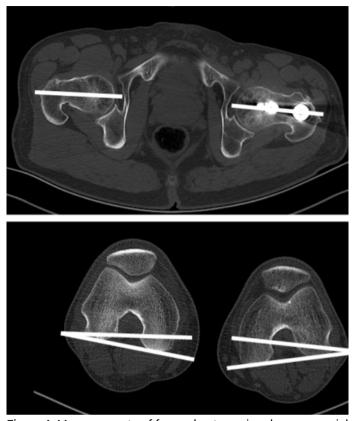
Measurements of femoral anteversion degree on axial CT view.
